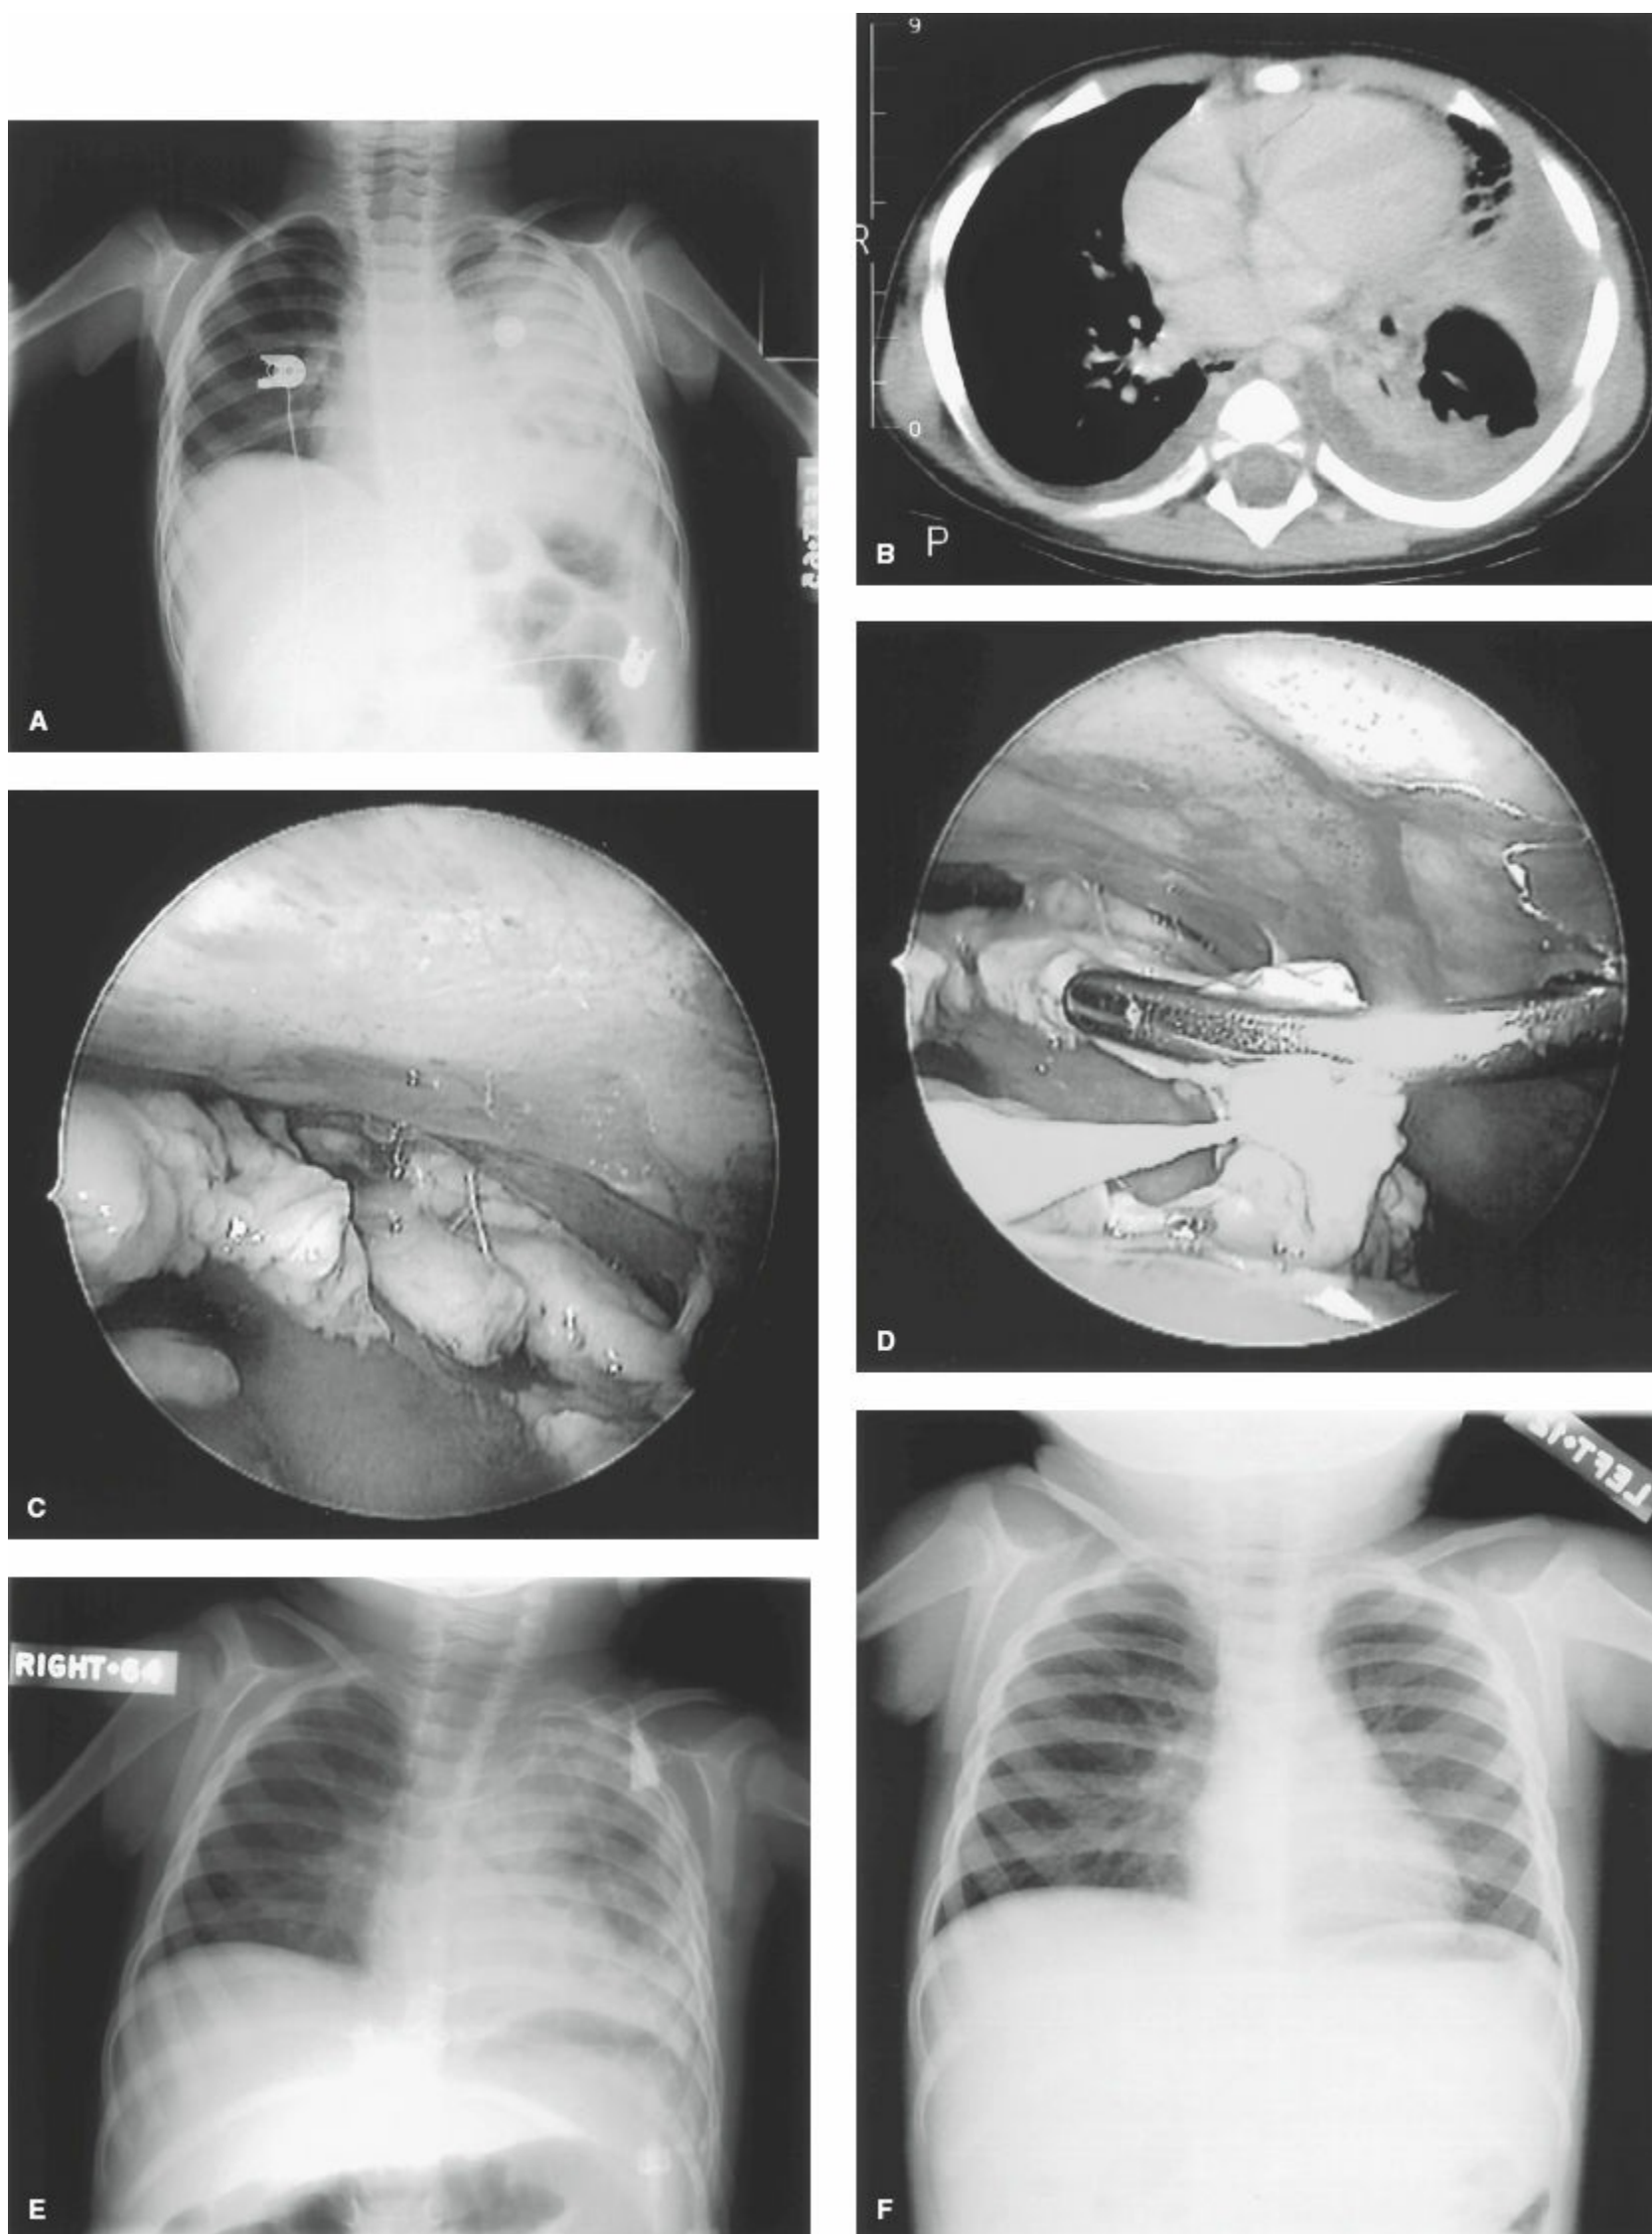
Video-assisted thoracoscopic treatment of complicated empyema in children. A: Chest radiograph of a 2-year-old child presenting with pneumonia and pleural effusion. B: Computerized tomography demonstrates complicated pneumonia with loculated empyema. C: Video endoscopic view of organized empyema debris. D: “Decortication” procedure includes removal of all loculated, organized debris from the hemithorax. All surfaces of the visceral and parietal pleura are accessible using video endoscopic techniques. E: Immediate postoperative chest x-ray shows the expected residual parenchymal lung disease. F: One month later, the chest radiograph findings have resolved.
